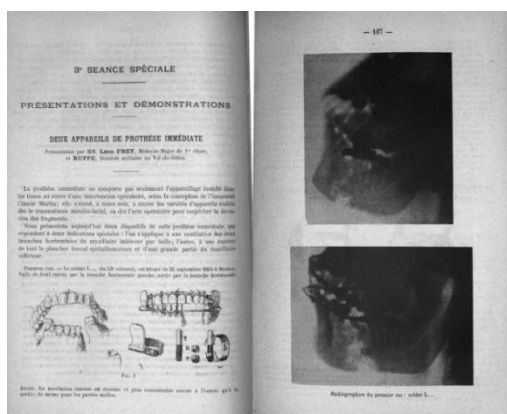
4, Anon., *Soldier L.*, 1915, X-ray, reproduced in Georges Villain (Ed) *Congrès Dentaire Interalliés-Comptes Rendus*, Paris, accessed April 7, 2021. https://archive.org/details/BIUSante_92939/page/n189/mode/2up
